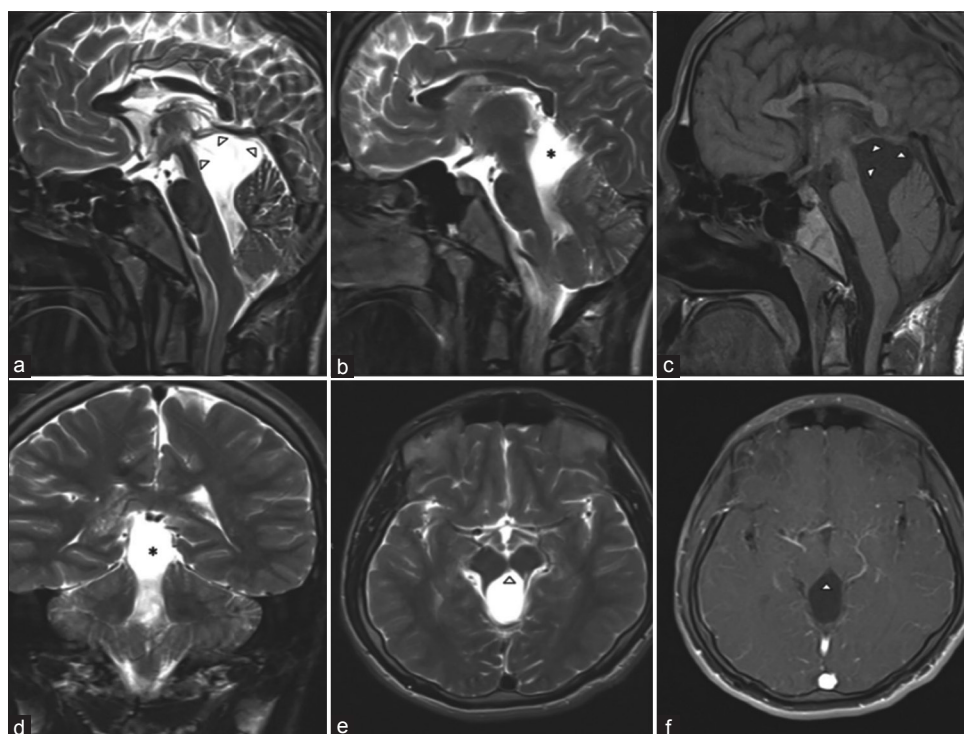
Intraventricular cyst causing dilation of the fourth ventricle and cerebral aqueduct. (a, b, d and e) Mid-sagittal, coronal, and transverse T2-weighted sequences. (c) T1-weighted mid-sagittal section. (f) T1-weighted transverse section after intravenous contrast administration. The content of the cyst (asterisks) exhibits signal intensity comparable to the cerebrospinal fluid in all sequences, distinguished from the turbulent flow of the intraventricular cavity outside the cyst. The fine cyst wall is noticeable in the superior and anterior portions (arrow heads)
